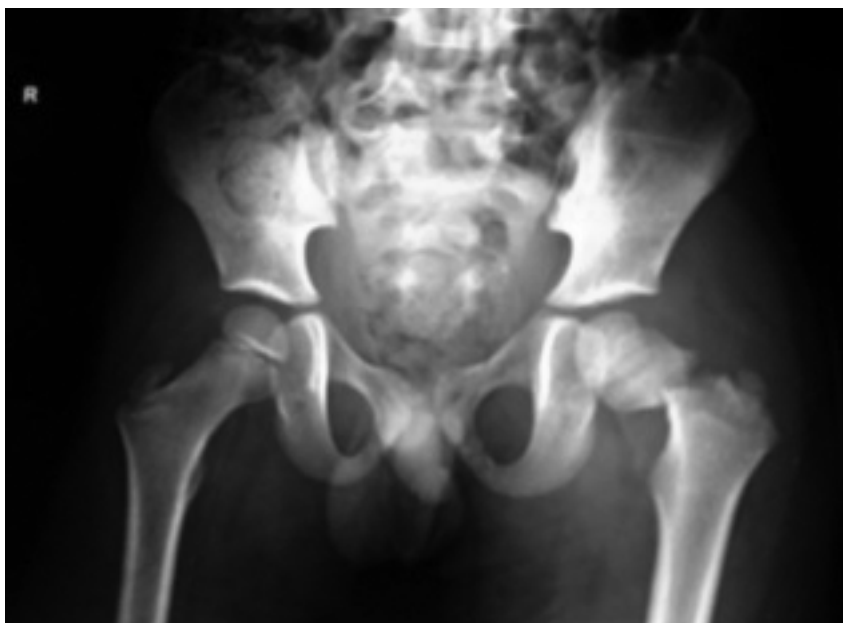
A plain radiograph of pelvis with both hips (AP view) showing displaced femoral neck fracture (type III).
